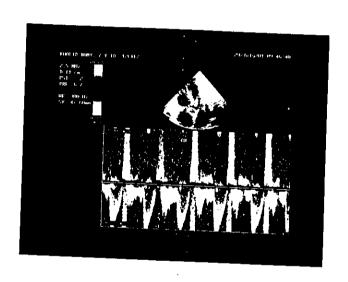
Echocardiography of 15 years old male patient with CRF shows AR.
